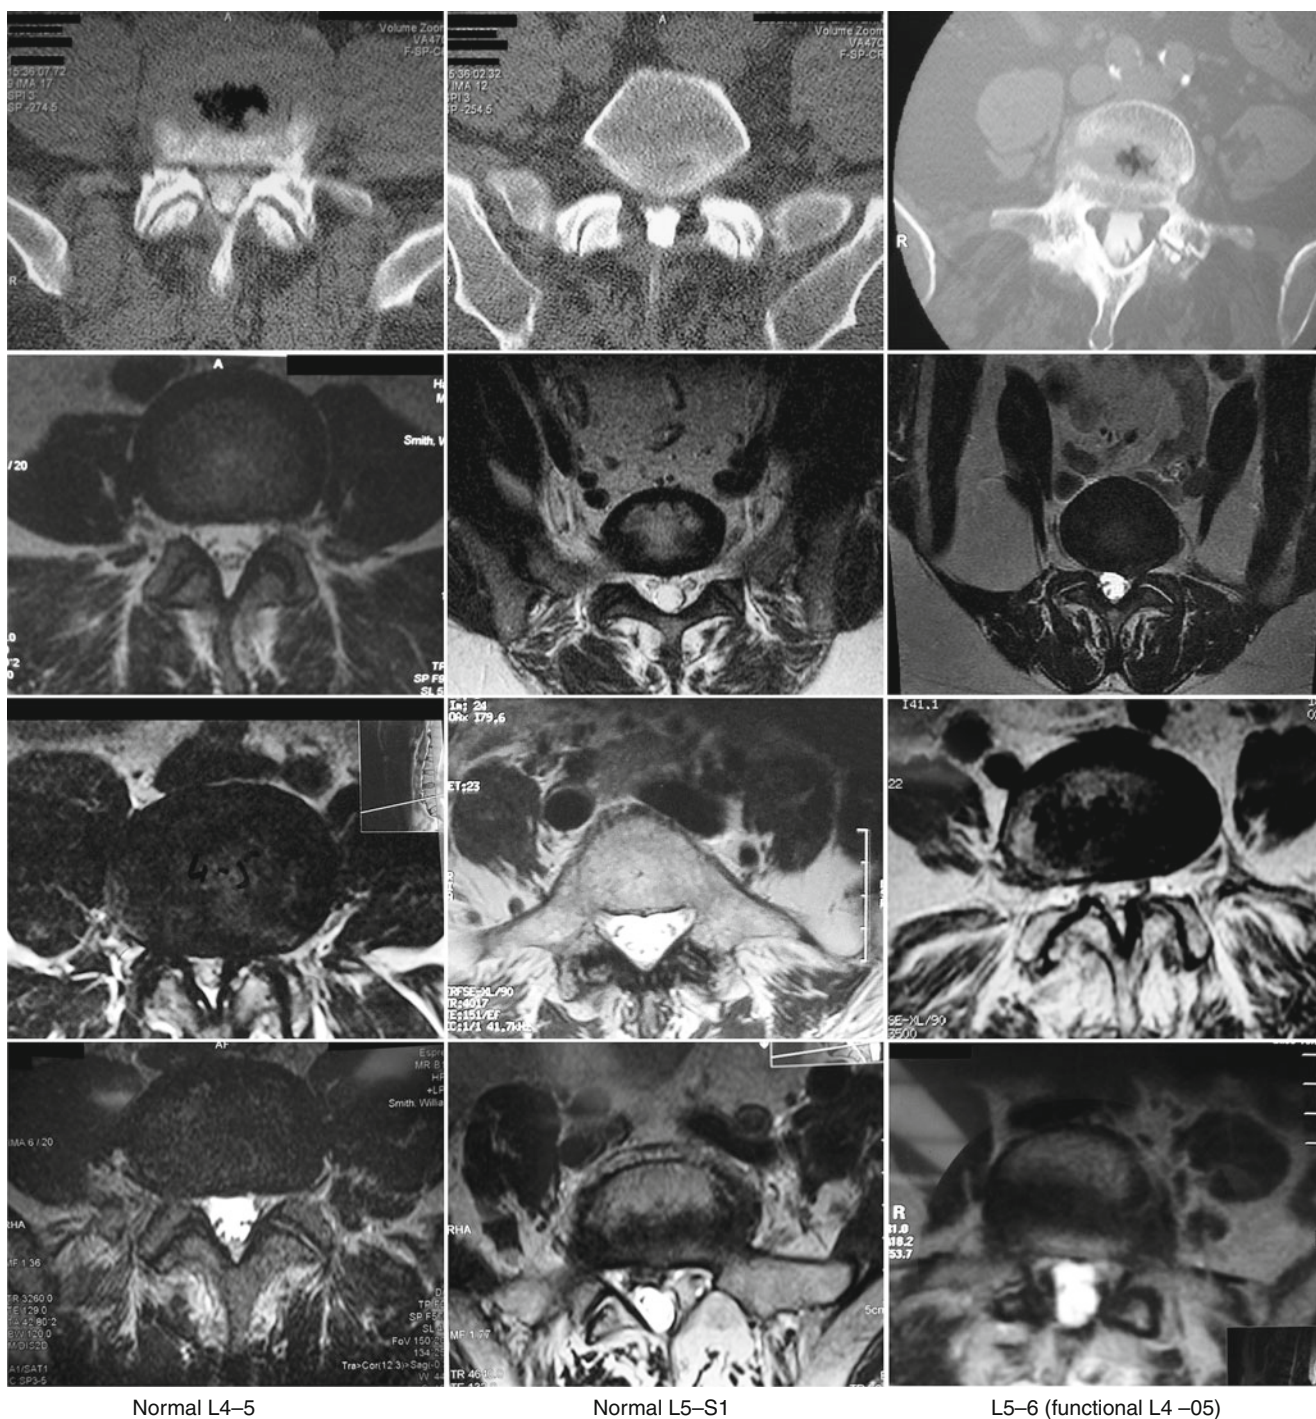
Examples of magnetic resonance imaging and computed tomography showing psoas muscle orientation at normal L4–5 discs (left), normal L5–S1 discs (center), and at L5–6 (functional L4–5) discs (right). Note the helmeted, attached orientation of the psoas muscles at
